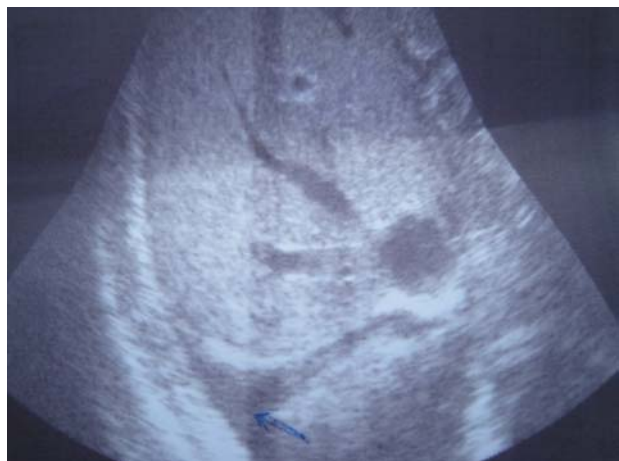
Abdominal ultrasound showed ascites without hepatosplenomegaly
